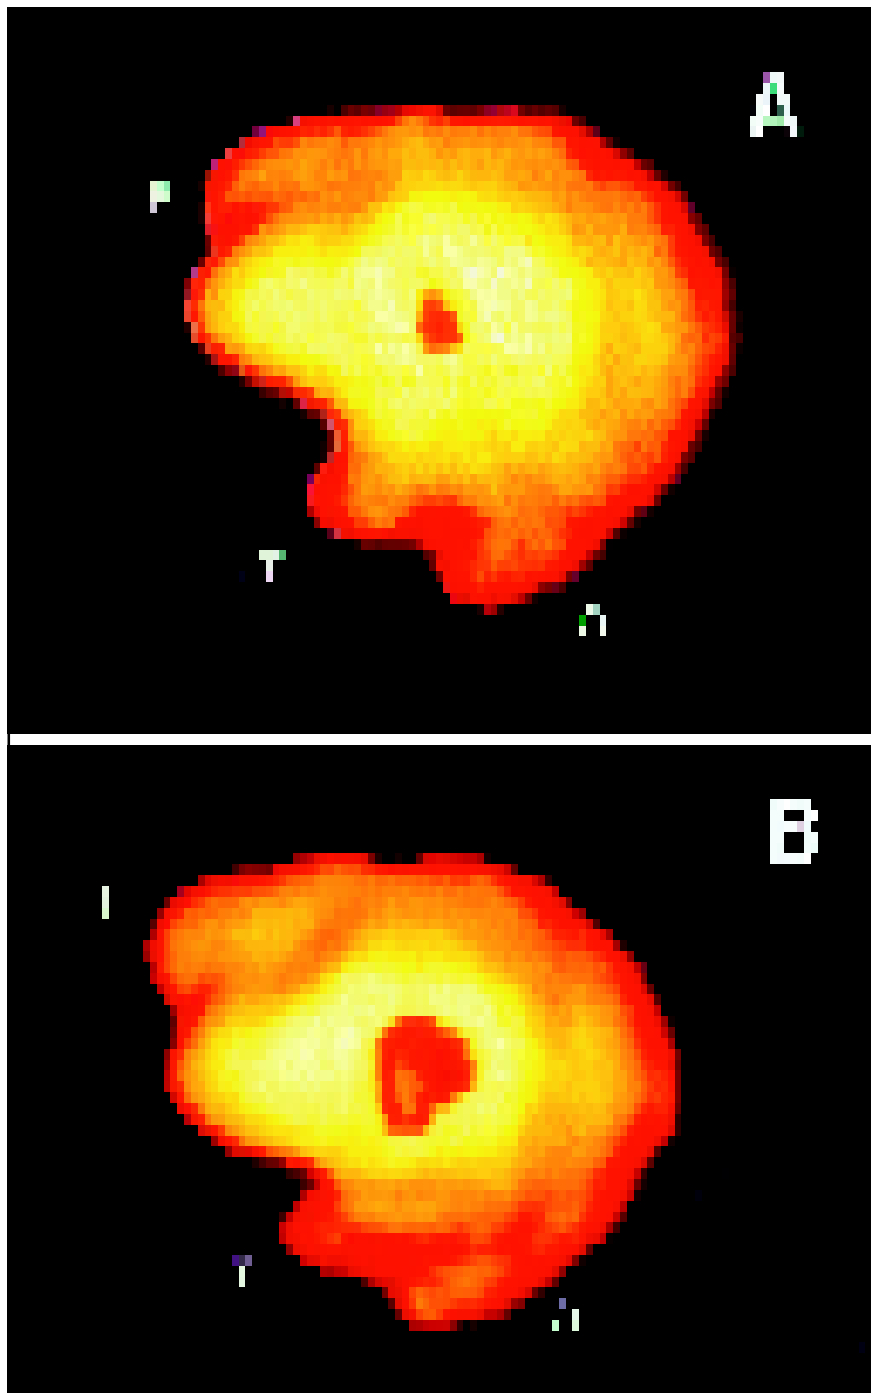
(A) right and (B) left lateral views of HMPAO-Tc SPECT disclose marked hypometabolic areas (darkened red), more evident at the left side, corresponding to frontal motor cortex. F - frontal pole; O - occipital pole; T - temporal apex.
